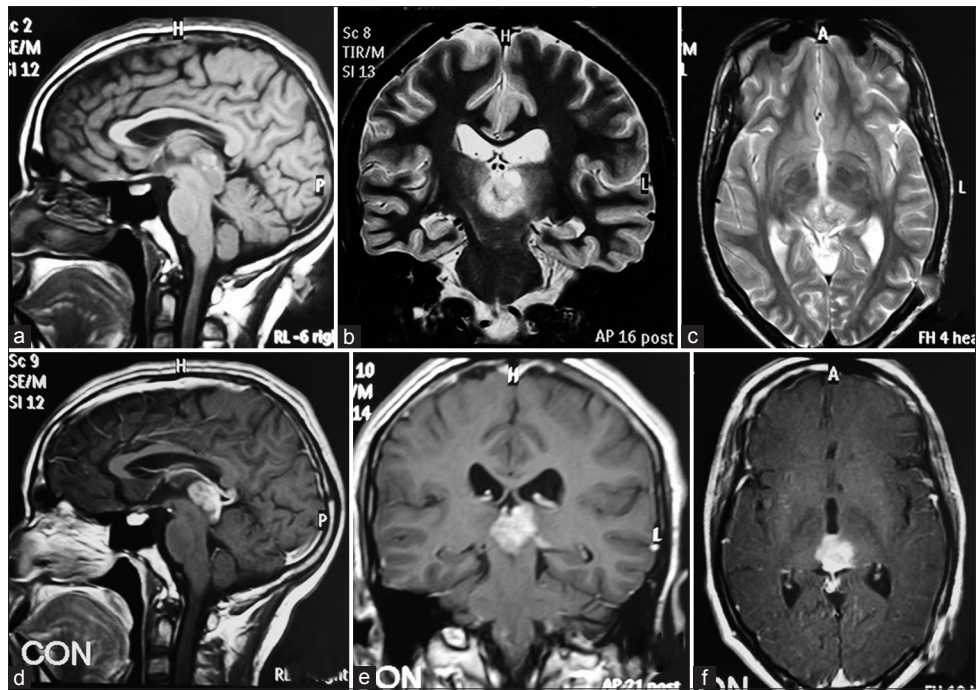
Initial MRI study of the patient. The top panel depicts the plain images: (a) T1-weighted (W) sagittal, (b) T2W coronal, and (c) T2W axial. The tumor is seen as a well-defined lesion in the pineal region iso- to hyperintense to the gray matter. A few cysts are visualized in b and c. There was no significant hydrocephalus. The bottom panel demonstrates corresponding MRI sections after gadolinium administration revealing a significant postcontrast enhancement. (d) Sagittal, (e) Coronal and (f) Axial images define the relationship of the lesion to the deep venous system
